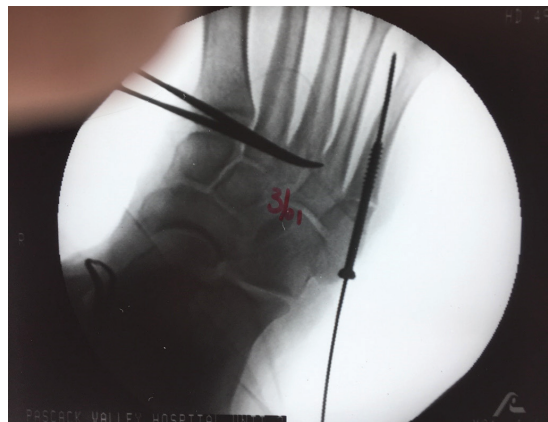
Intra-operative fluoroscopy of a Jones fracture showing the placement of a cannulated screw. A wire is inserted from the base of the styloid process into the medullary canal. The placement is checked and if acceptable, a cannulated screw of proper size is placed over the wire. A 3.5 or 4.0 mm. partially threaded screw can be used in most cases. When the screw was in place, the fluoroscope was used to check proper placement, making sure the threaded portion of the screw was across the fracture site. When the placement was assured, the wire was removed, leaving only the screw in place. With experience, most surgeons can learn to screw fixate without using fluoroscopy. It is still strongly suggested that a post-operative radiograph be taken before leaving the OR to ensure proper placement.
